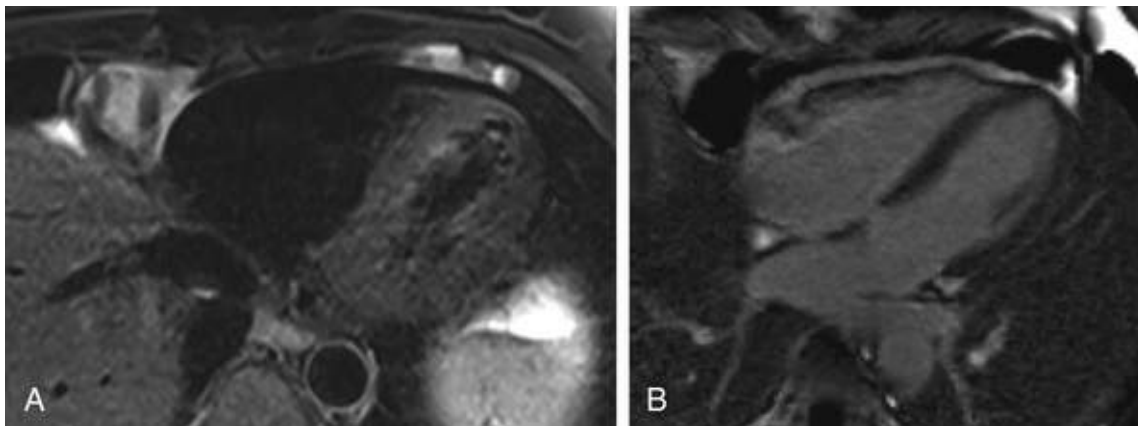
Pericardial cyst in 47-year-old woman presenting with a history of shortness of breath and palpitations and found to have a mass next to the right atrium on chest radiograph and then referred for CMR. Homogeneous mass (*arrow*) is seen abutting the right atrium and upper right ventricle without significant mass effects. Matching T2 images showed that this mass is bright, indicative of a simple fluid content (see eFig. 17.1A), which does not enhance after contrast (eFig. 17.1B).
